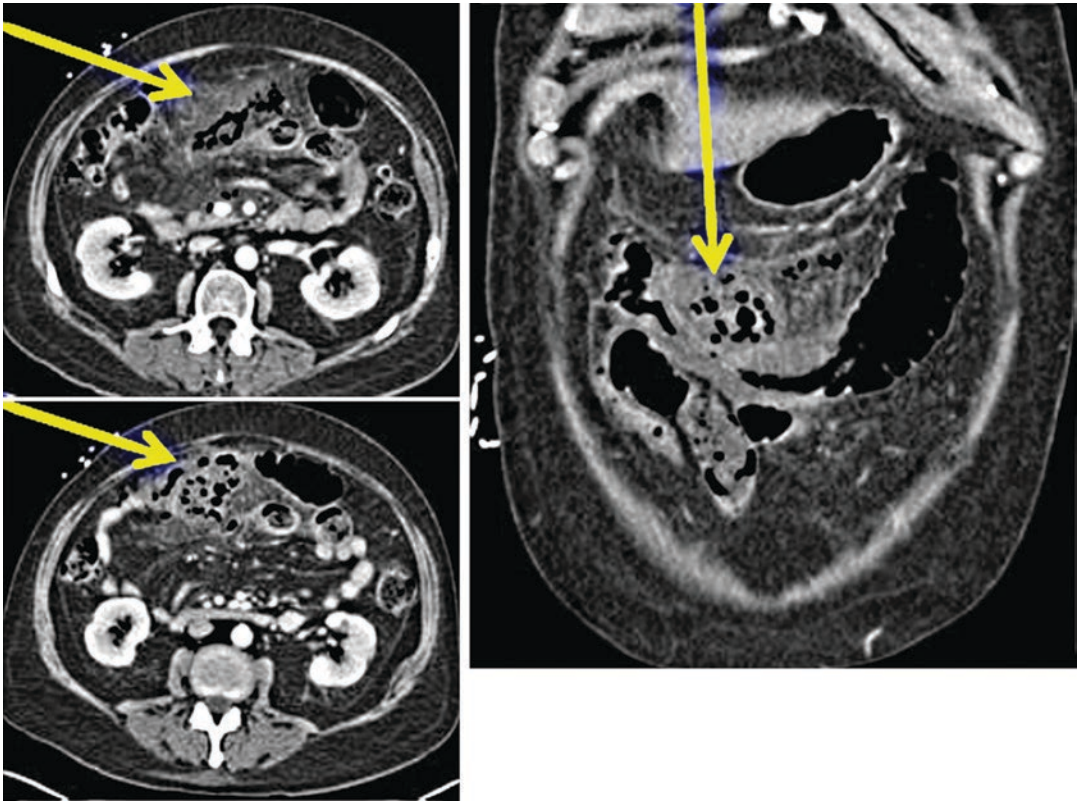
CT scan imaging demonstrating inflammatory changes around the mid-transverse colon with extraluminal air and fluid in this area, consistent with a perforation of the transverse colon and peritonitis
